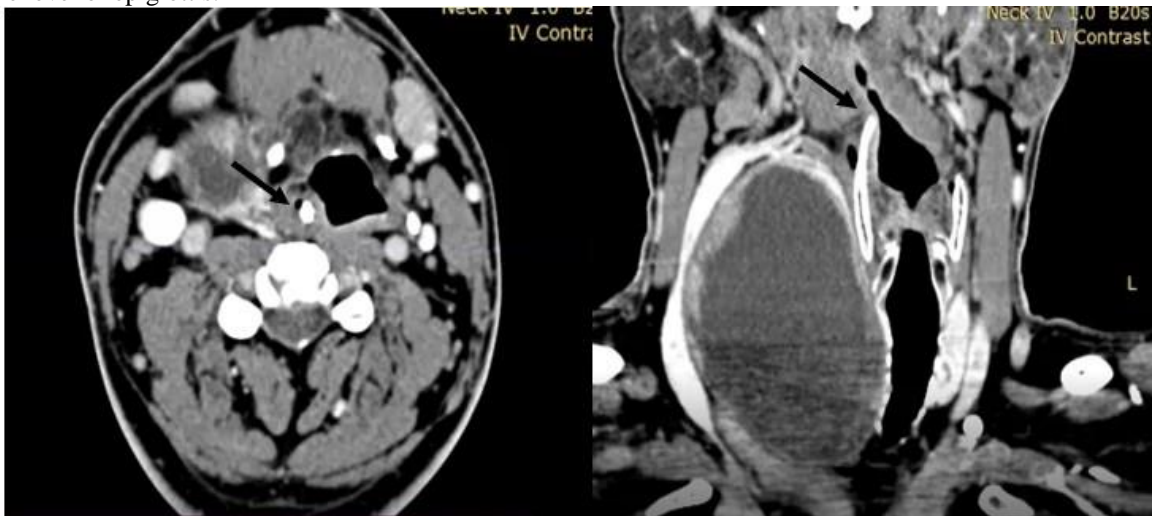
A CT-scan of the neck from axial and coronal view showed a well-demarcated cystic lesion at the right thyroid lobe that pushes larynx and trachea to the left superior.
